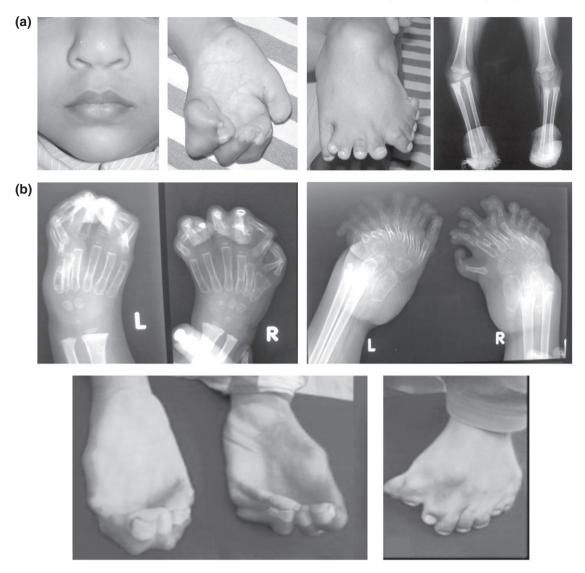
Families 3 and 4 show the characteristic features of Laurin-Sandrow syndrome (LSS) including complete syndactyly of the hands and mirror image polysyndactyly of the feet. (a) Family 3 with one affected boy who presented with nasal defects, bilateral polysyndactyly of the hands and mirror image polysyndactyly of the feet. Radiograph of the feet showed symmetrical mirror image polydactyly of the metatarsal bones and toes as well as duplication of the fibula. (b) Family 4 is a consanguineous family from Pakistan with three affected individuals. All affected showed a cup-shaped polysyndactyly of the hands combined with mirror image polysyndactyly of the feet.
